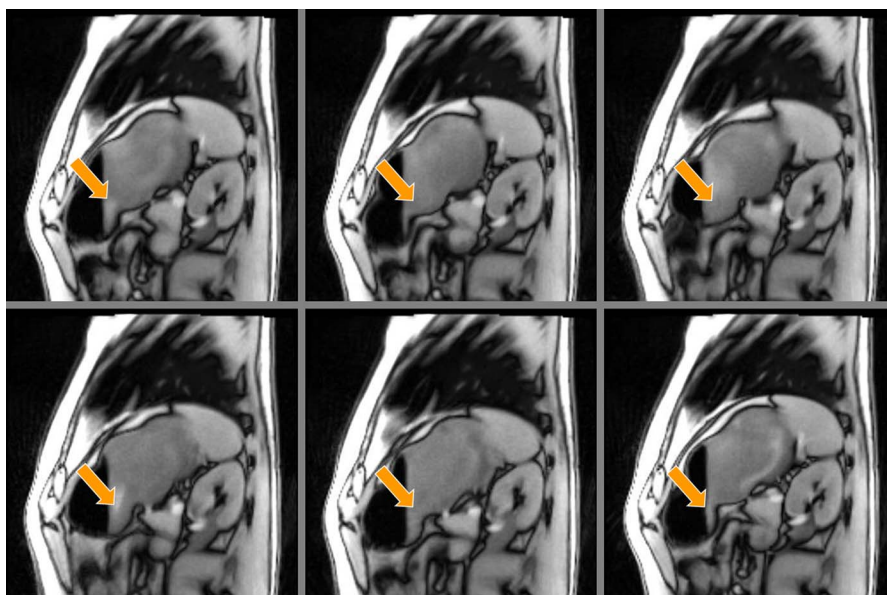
Stomach motility. Selected frames (oblique views from top left to bottom right, same section) of a simultaneous triple-slice real-time MRI acquisition of the movements of the muscular wall (3×40 milliseconds acquisition time, 1.5 mm resolution, 8 mm slice thickness). The frames are 3×30 images apart (3.6 seconds) and cover one cycle of slow contractions and expansions (see arrows).
